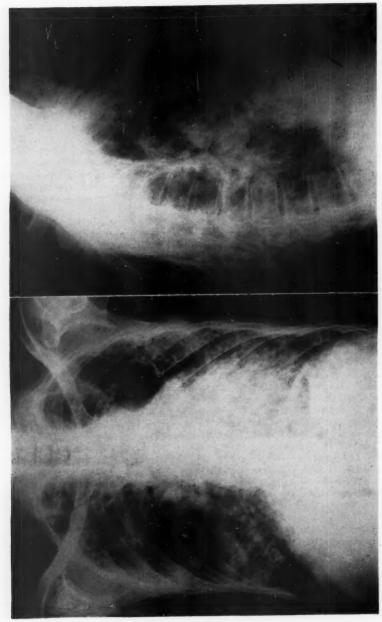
Case 5. Chest x-ray.
